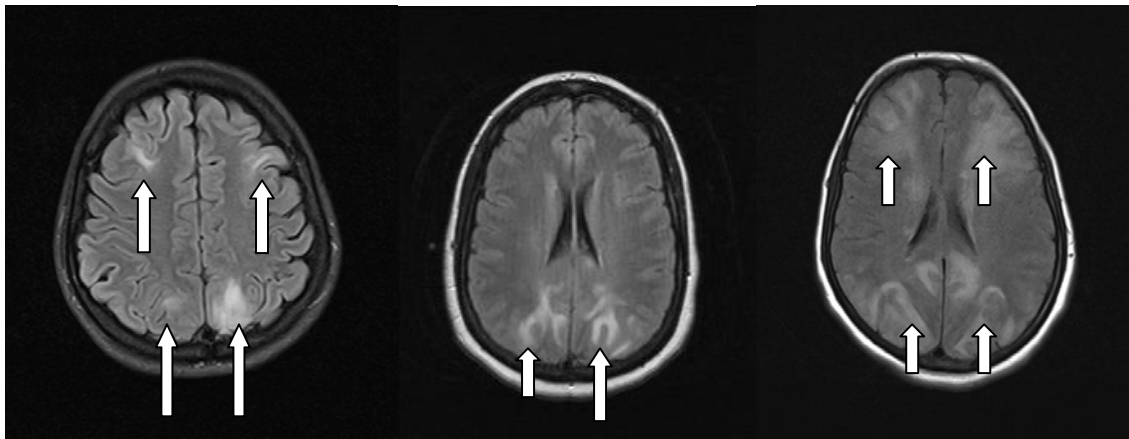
Axial FLAIR images showing cortical and subcortical hyperintense lesions in frontal, parietal and occipital lobes, representing vasogenic edema.
